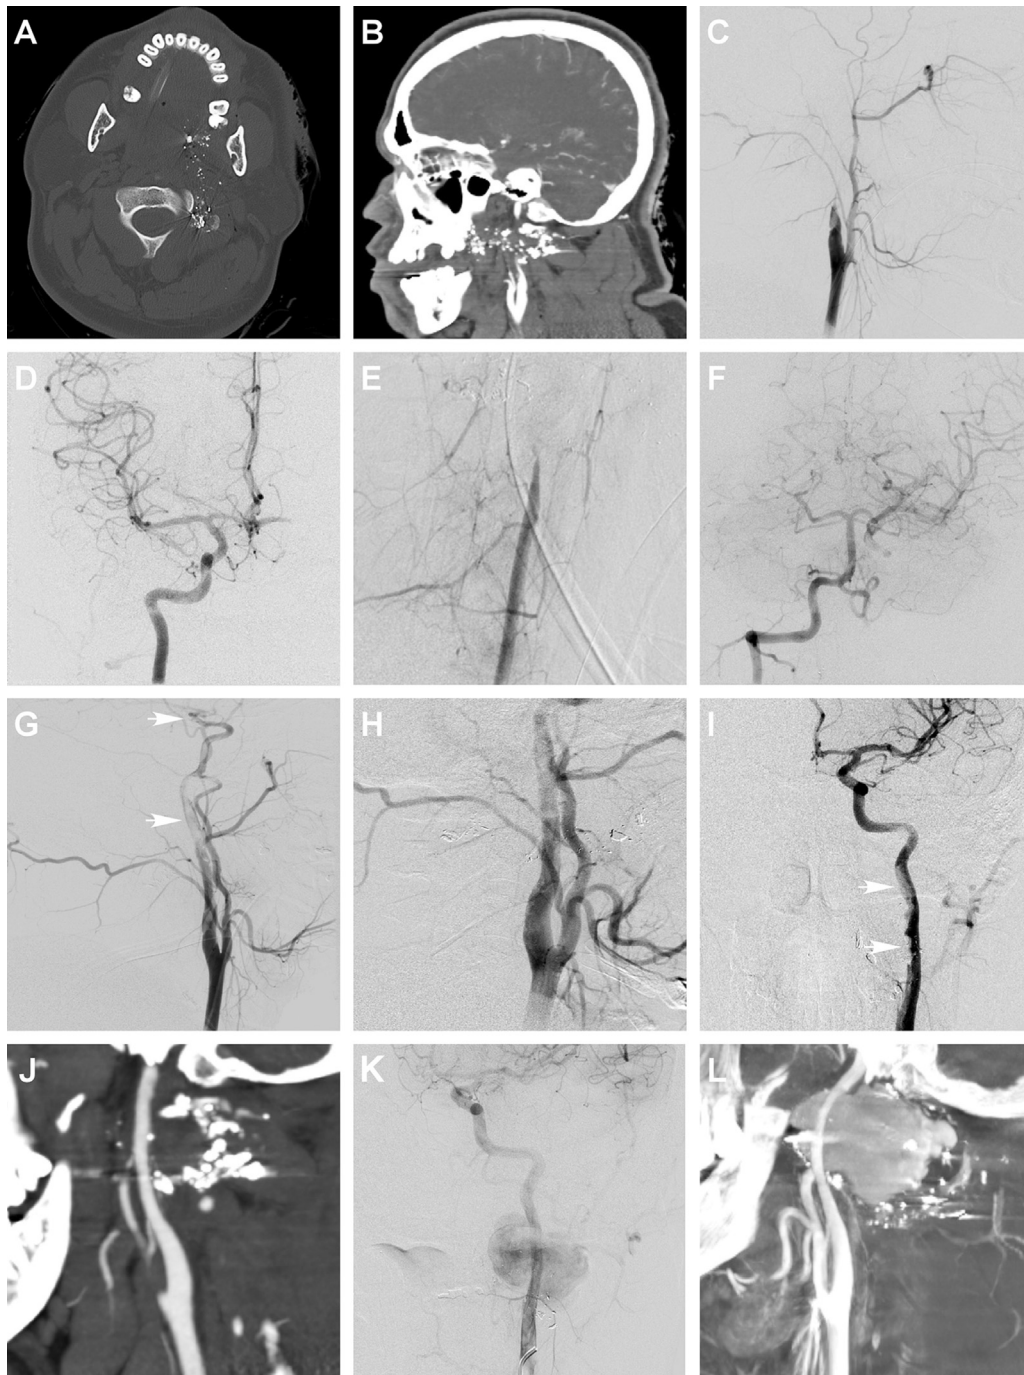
(A and B) Initial presentation imaging. (A) Axial CT head demonstrating the gunshot wound and bullet fragments. (B) Maximum intensity projection CTA sagittal reconstruction demonstrating dissection of the ICA as well as bullet remnants filling the posterior oropharyngeal space. (C–F) Digital subtraction angiography (DSA). (C) Lateral left CCA injection demonstrating left ICA dissection with complete interruption of distal flow. (D) AP right ICA injection shows collateral circulation to the contralateral hemisphere. (E) AP left vertebral artery injection shows total occlusion at the level of C2. (F) Right vertebral artery injection demonstrates collateral circulation to the contralateral hemisphere. (G) Three days post-trauma, left CCA injection lateral view demonstrates partial recovery of flow in the left ICA with distal thrombus formation (arrows). (H) 8 days post-trauma, lateral left CCA injection, demonstrates total recovery of flow in the Left ICA. (I) AP projection of left ICA injection the same day demonstrates extensive thrombosis over the distal segment of the ICA at the supraclinoid level (arrows). (J) Maximum intensity projection CTA sagittal reconstruction 12 days later, after patient re-presented with hoarseness and dysphagia demonstrates continued recanalization of the dissected left ICA with no evidence of pseudoaneurysm formation. (K and L) Angiography six weeks post-trauma demonstrating a large, low-flow pseudoaneurysm. (K) AP left ICA DSA. (L) Left ICA injection cone-beam CTA maximum intensity projection sagittal reconstruction.
